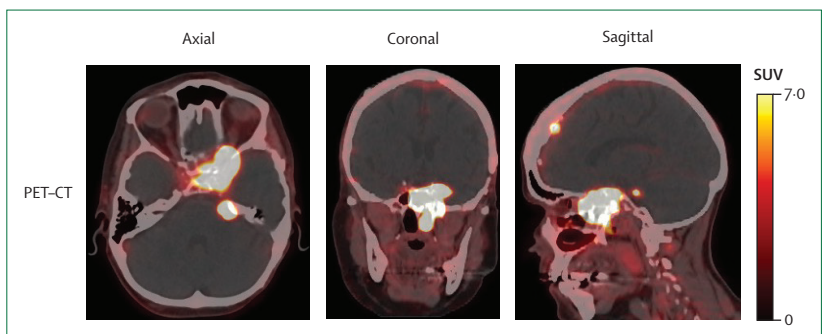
SSTR2 PET-CT scan of a patient with multifocal recurrence of a sphenoid wing meningioma, CNS WHO grade 2, after surgical resection and irradiation
